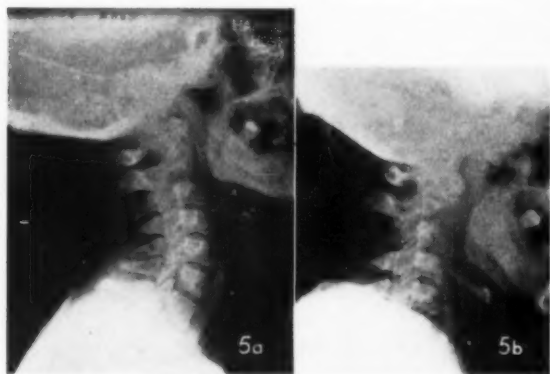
X-ray of the cervical spine.
